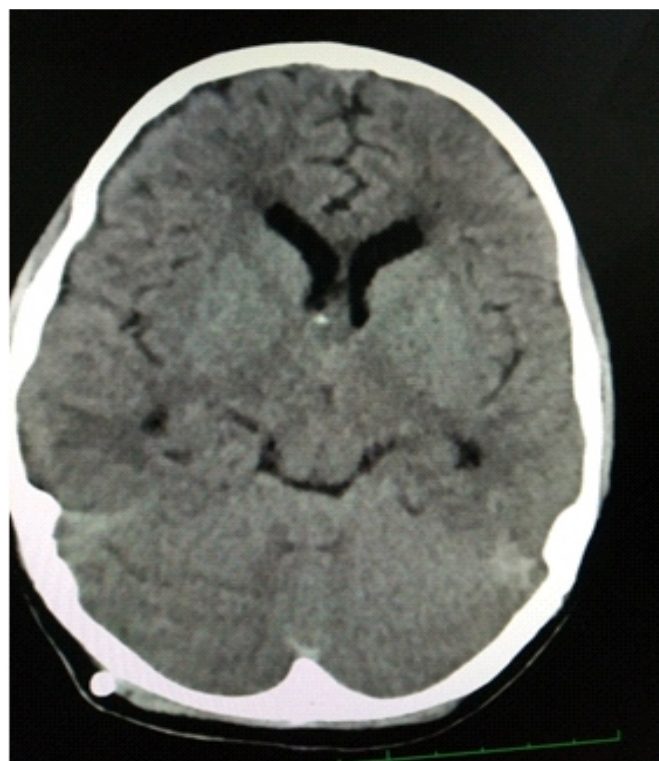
Post operative CT showing normal sized ventricles and cyst displaced
